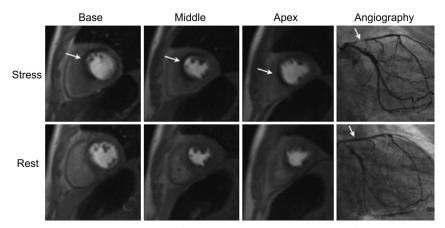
Stress CMRI. Myocardial perfusion analysis during vasodilator infusion in a 74-yearold man with chest pain at mild exertion, known 2-vessel CAD, and no wall motion abnormalities. The top row shows 3 short axis views (basal, midventricular, and apical) during contrast-enhanced first-pass perfusion CMR imaging during adenosine stress. A large perfusion defect of the anterior and septal wall is obvious (*white arrows*). The bottom row shows the same slices during contrast-enhanced first-pass perfusion CMR imaging at rest, with clearly less extensive perfusion defect. On the right side, the coronary angiography is depicted. A severe stenosis of the proximal left anterior descending artery, which supplies the anterior and septal wall, is seen (*white arrow in the top image*). It is treated by stent implantation (*white arrow in the bottom image*). (*From* von Knobelsdorff-Brenkenhoff F, Schulz-Menger J. Cardiovascular magnetic resonance imaging in ischemic heart disease. J Magn Reson Imaging 2012;36:24; with permission.)
